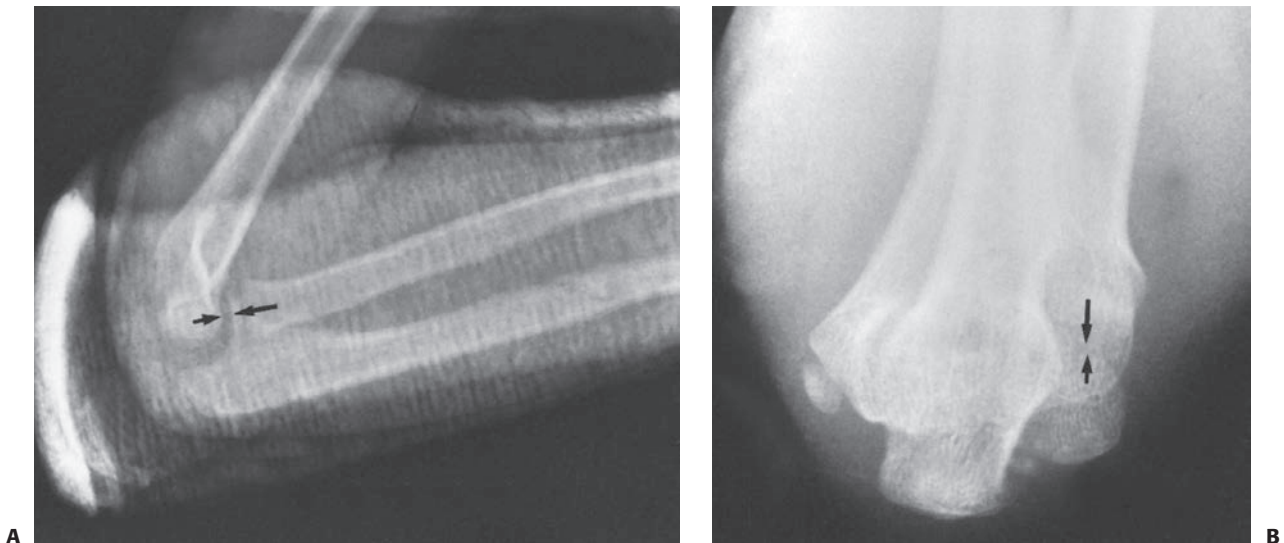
Once the close reduction is complete, radiographs should be analyzed for reestablishment of the radiocapitellar line (arrows) and ulnar alignment on both the lateral (A) and Jones (B) views.
